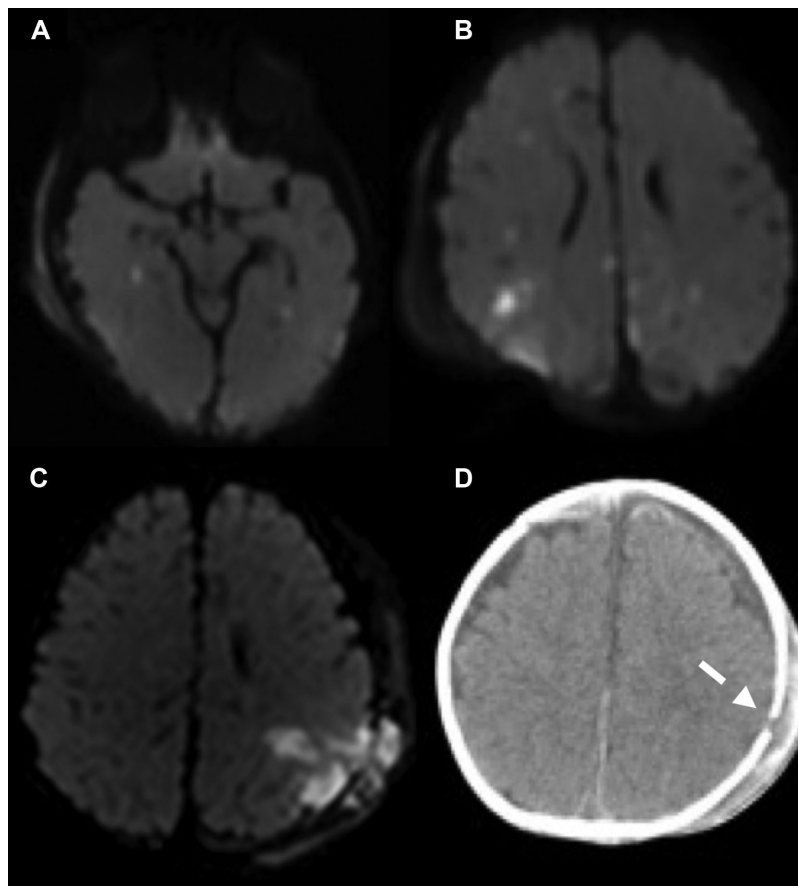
Images A and B show diffusion tensor images obtained on the day of admission in a 2-month-old boy with punctate areas of restricted diffusion at the cortico-subcortical junction compatible with diffuse axonal injury. The patient also had a left parietal comminuted fracture and bilateral, right greater than left subdural hematomas. The child developed long-term seizures in the follow-up. Images C and D show the case of a 3-month-old boy with a left parietal skull fracture (dotted arrow) with associated bilateral subdural hematomas, better seen in the CT axial image (D). There is an associated parenchymal ischemic contusion with cytotoxic edema (C). The child developed severe language delay, seizures, and a cephalocele at the level of the fracture.
